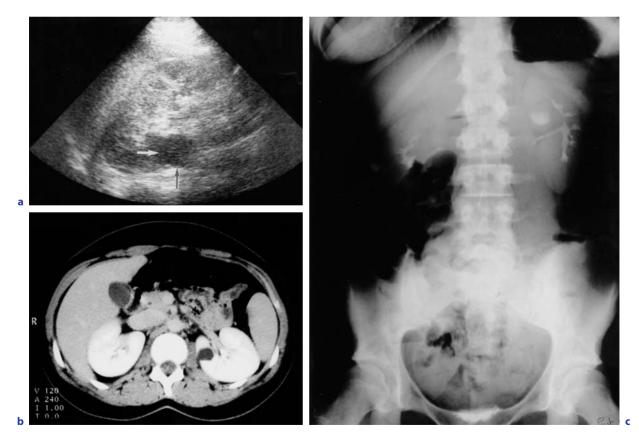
Calyceal diverticulum. a US: sagittal scan of the left kidney; a hypoechoic mass is visualized posteriorly (*arrows*). b CT scan after contrast enhancement: the cystic structure seen in the left kidney contains a fluid/contrast level suggesting a connection with the pyelocalyceal system. c IVU: the calyceal diverticulum is clearly opacified
